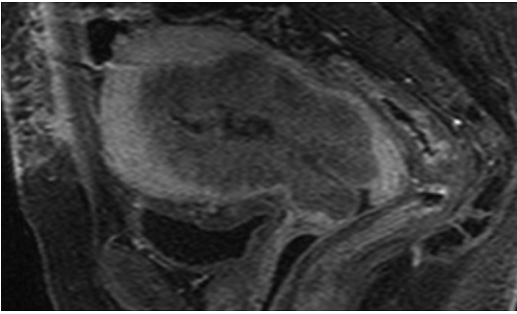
Endometrial carcinoma with myometrial and cervical invasion. DCE-MR imaging. Three-dimensional T1-weighted fast-spoiled gradient-recalled sagittal section.
